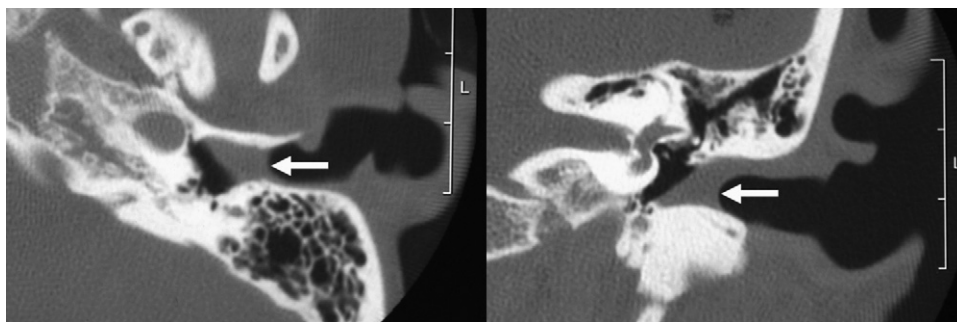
Representative high resolution computed tomographic scans in a patient with medial meatal fibrosis (case 1), showing a soft tissue density (arrows) on the medial aspect of the external auditory canal without abnormalities in the middle ear spaces. Left: horizontal plane; right: coronal plane.
